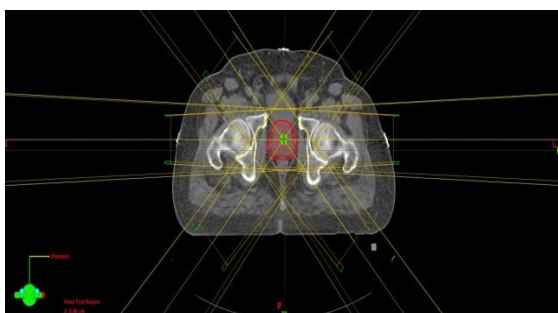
presents an axial computed tomography slice showing a 3D-CRT plan with PTV contoured and six fields.
